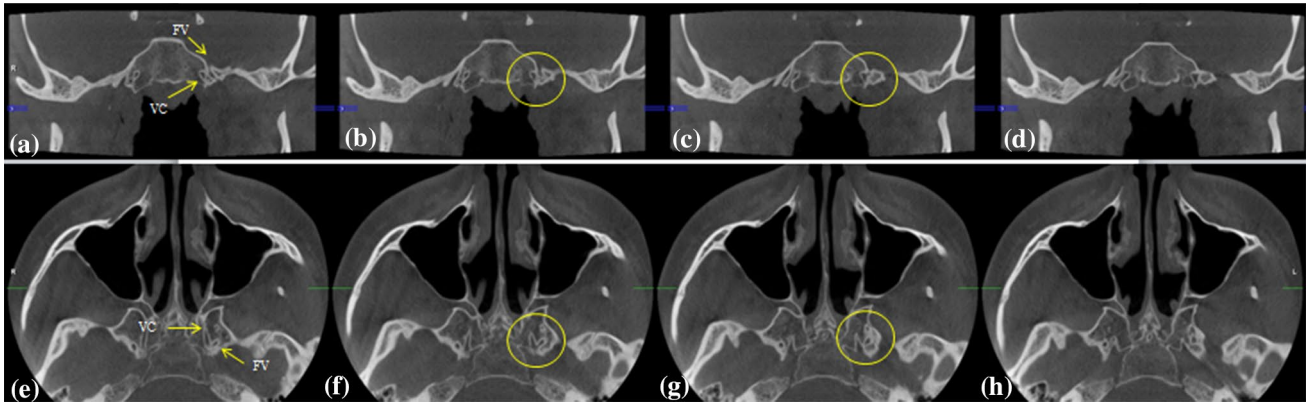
Coronal and axial CBCT slices showing the middle cranial fossa (a–h). This case shows the FV communicating with the VC (yellow circles) on the left side, c and f. FV foramen venosum, VC vidian canal, L left, R right
